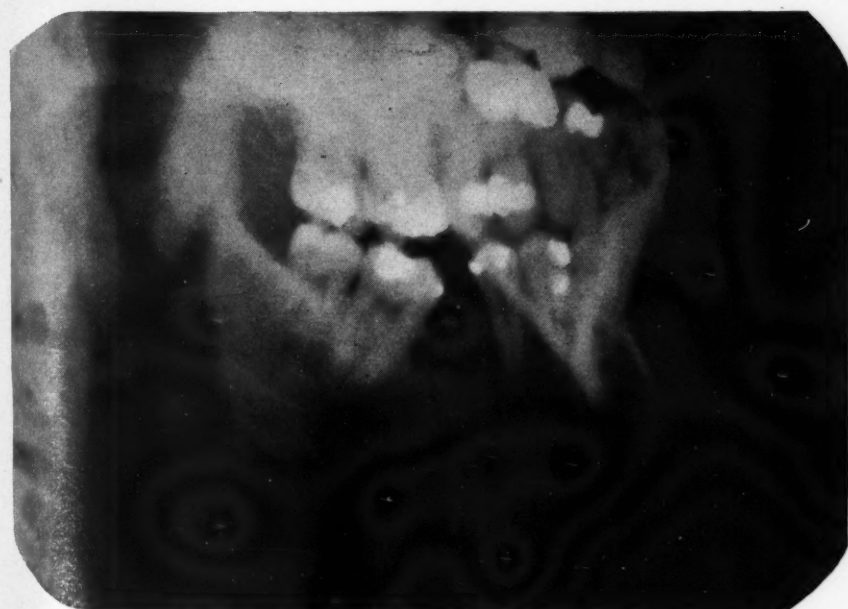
FRACTURED (BROKEN) JAW BONE. The "x-ray" is a valuable adjunct in making a diagnosis of a fracture, as it aids in determining the type, location, and severity of the break. Fig. 20 shows a multiple fracture of the right side of the lower jaw, resulting from an accident.
